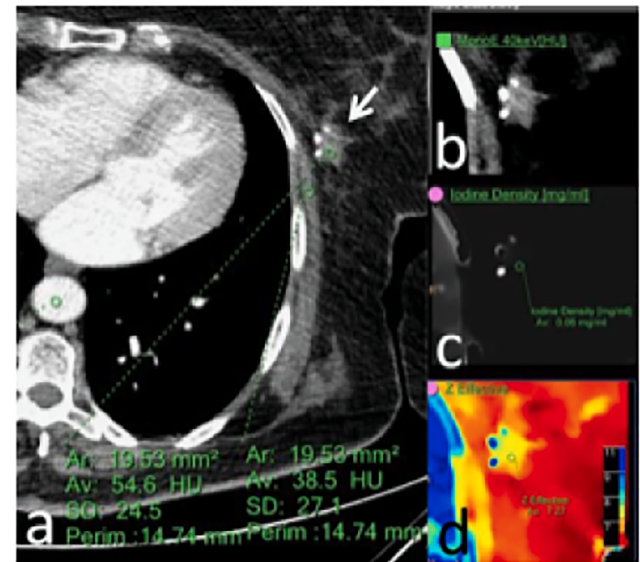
68 year-old female, follow-up imaging of the patient with a history of invasive atypical lobular carcinoma of the left breast who had been treated conservatively in 2005. (a) Scar tissue with irregular margins in the lower lateral quadrant with a density of 54.6 HU on the conventionally displayed CT-images (arrow). (b) Lower keV (40 keV) VM images show no significant attenuation difference indicating contrast uptake in scar tissue. (c) Iodine density-map demonstrates lack of iodine in scar tissue (0.06 mg/ml). (d) Zeffective-map shows low atomic number of the scar tissue (7.27) without iodine content. The appearance of the scar tissue was stable between 8/2016 and 3/2019 on X-ray mammography.
